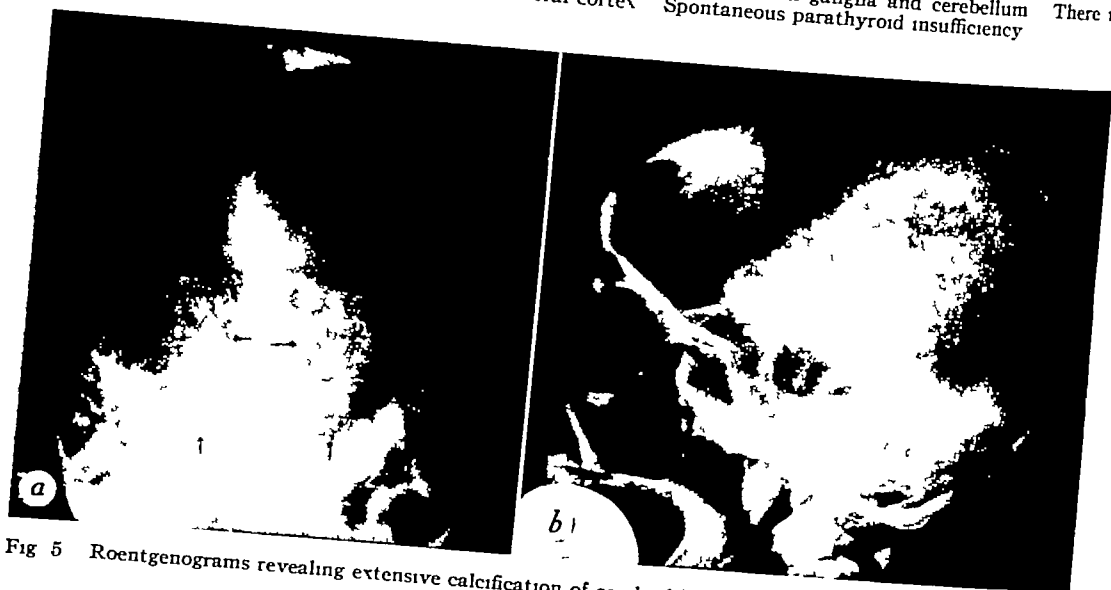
Roentgenograms revealing extensive calcification of cerebral basal ganglia. Postoperative parathyroid insufficiency.
